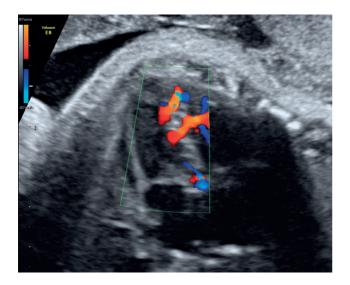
Color Doppler image of a double apical ventricular septal defect in portion of muscular septum located below the moderator band.
